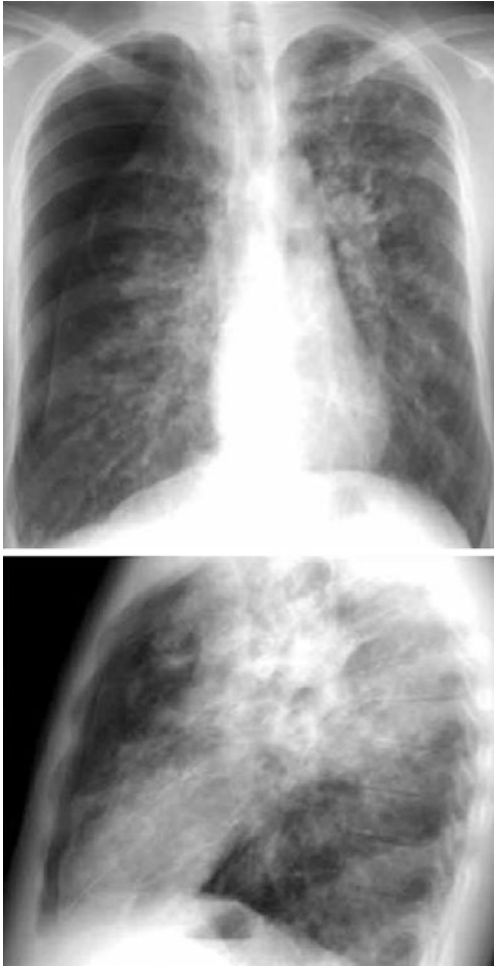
Pneumothorax in Chronic Disease. Anteroposterior and lateral chest X-ray of a 14-year-old patient with cystic fibrosis and advanced lung disease. It shows lateral and anterior pneumothorax on the right side
